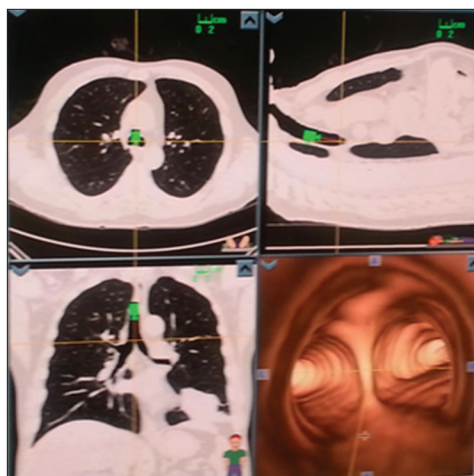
Electromagnetic navigational bronchoscopy preplanning screen with four viewports showing axial, coronal and sagittal computed tomography views and virtual bronchoscopy view
